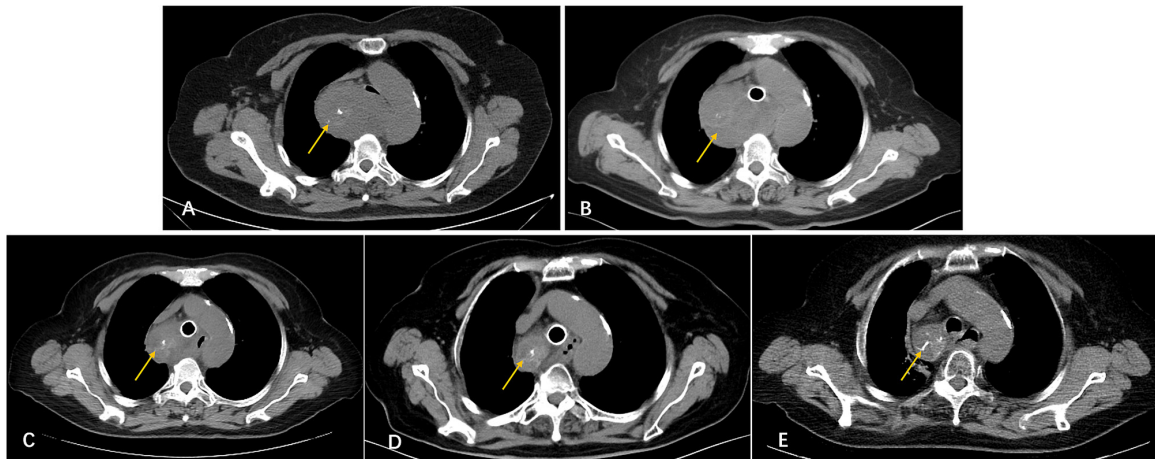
Chest computed tomography before and after treatment. (A) Soft tissue mass measuring 8.5x6.2 cm (yellow arrow) at the maximum cross-sectional area in January 2022. (B) Soft tissue mass measuring 8.3x6.2 cm (yellow arrow) at the maximum cross-sectional area in March 2022. (C) Soft tissue mass measuring 5.5x4.8 cm (yellow arrow) at the maximum cross-sectional area in May 2022. (D) Soft tissue mass measuring 3.5x2.4 cm (yellow arrow) at the maximum cross-sectional area in July 2022. (E) Soft tissue mass measuring 3.5x2.4 cm (yellow arrow) at the maximum cross-sectional area in July 2025.
